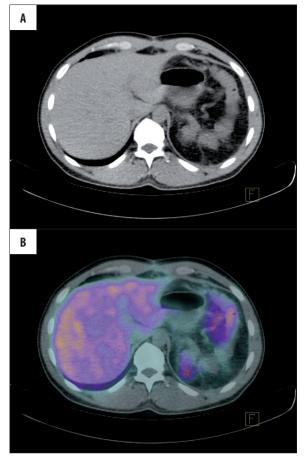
Patient K.A.: CT scan and PET-CT with gallium-68 labeled somatostatin analogues on 8 October 2008: no radiological changes in the left upper abdomen with physiological radiotracer uptake in the liver, intestine and kidney.
